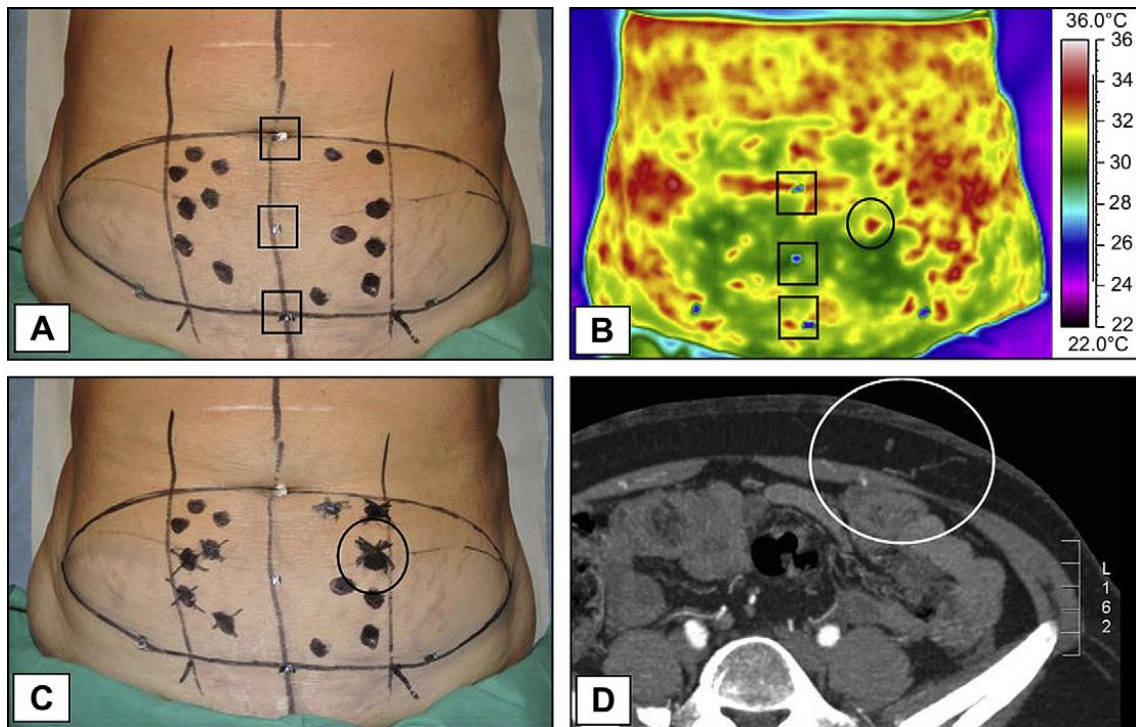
The flap is outlined on the lower abdomen (A). The black dots represent the locations where arterial Doppler sounds were registered. Small pieces of metal tape were used as reference marks (black squares in A and B). The IR thermogram (B) was taken 3 minutes after 2 minutes of fan cooling. The black circle indicates the first-appearing hot spot. In (C), locations of arterial sounds associated with hot spots are marked with an "X." The selected perforator is marked with a circle and correlates with a suitable perforator on the MDCT scan (white circle in D). Image from "Dynamic infrared thermography", used with author's permission [41]
